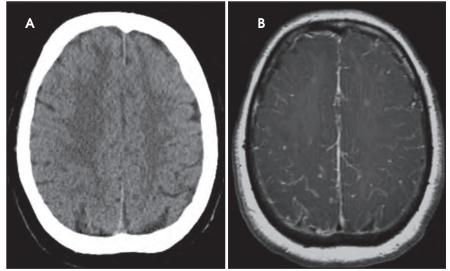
54-year-old woman with headaches, fevers, and confusion. (A) Unenhanced axial CT image is normal. (B) Postcontrast axial T1-weighted image demonstrates leptomeningeal enhancement due to streptococcus pneumoniae meningitis. The absence of such enhancement should not be interpreted as sufficient evidence to exclude meningitis.
